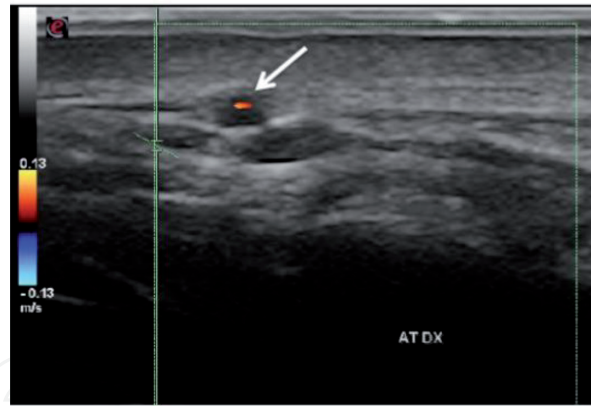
Color Doppler ultrasonography (CDUS) of the right TA shows a hypoechoic halo around the lumen in transverse view (arrow). The “halo sign” corresponds to edema of the artery wall. [11].
